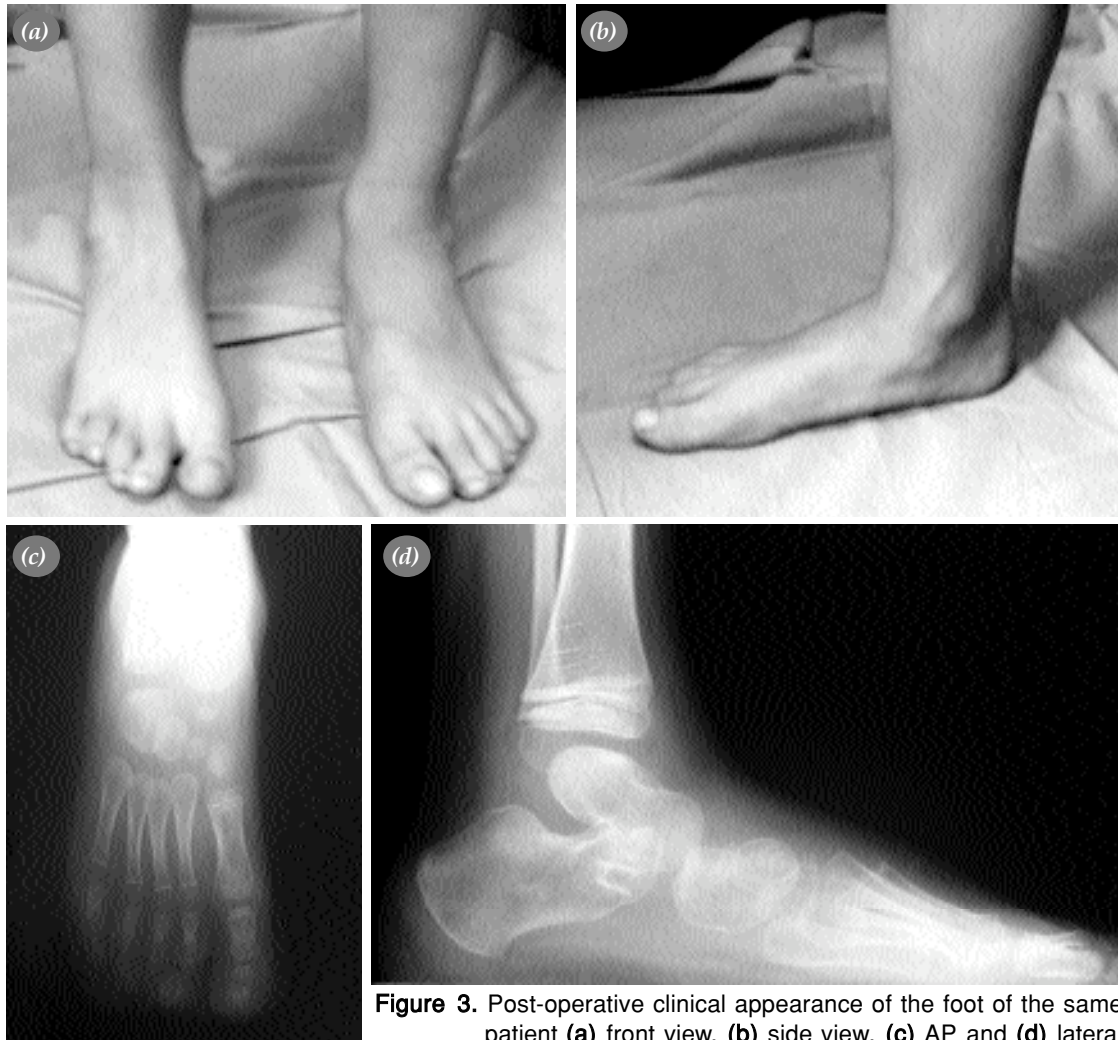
Post-operative clinical appearance of the foot of the same patient (a) front view, (b) side view, (c) AP and (d) lateral radiographies
